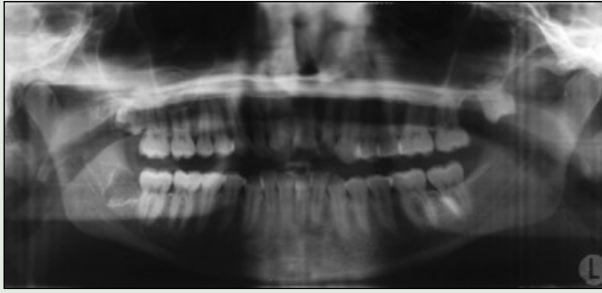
A panoramic radiograph is a useful baseline tool to demonstrate the location of the displaced maxillary third molar, in this case tooth 28.
